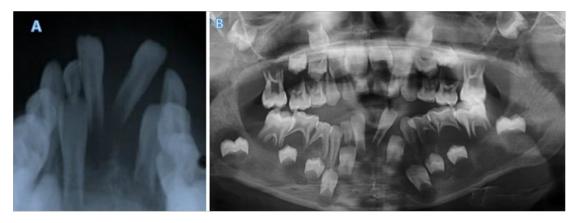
(A) Lower Standard Occlusal Radiograph and (B) Dentopantomogram (DPT) taken in November 2022, Showing Generalised Bone Loss in the Mandible
